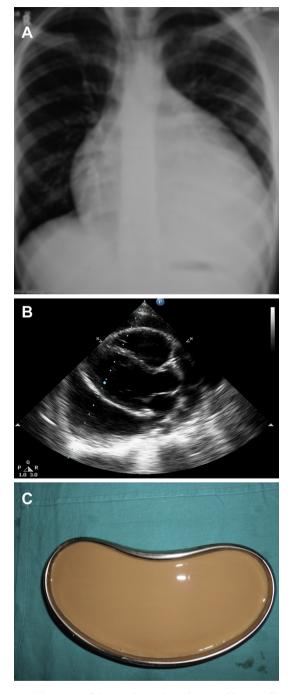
(A) X-ray of the patient showing cardiomegaly, (B) Echocardiogram showing pericardial fluid, (C) Tea-colored pericardial aspirate.
